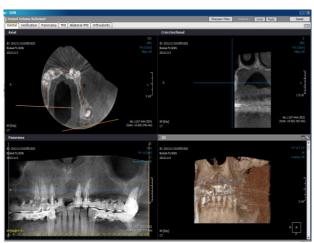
CBCT reveals a minor pneumatization at the level of 2.6, sufficient bone height at the level of 2.4 and 2.5 and significant bone loss at the level of aforementioned teeth.
